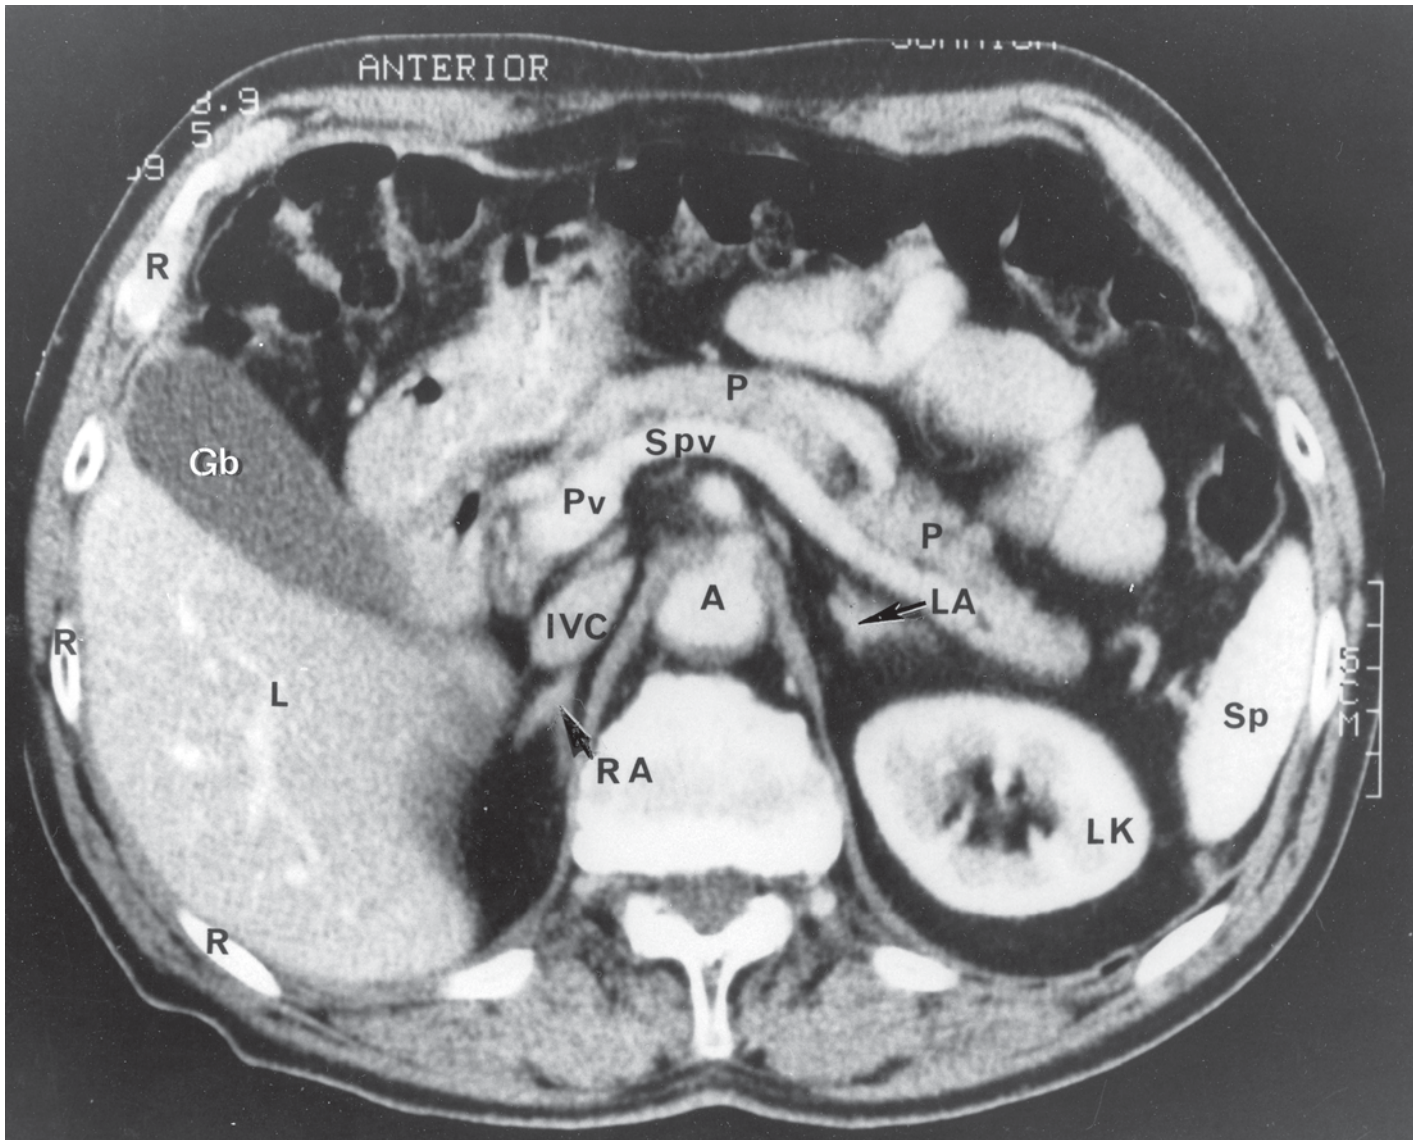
CT of the Upper Abdomen Showing the Organs at the Level of About L1
